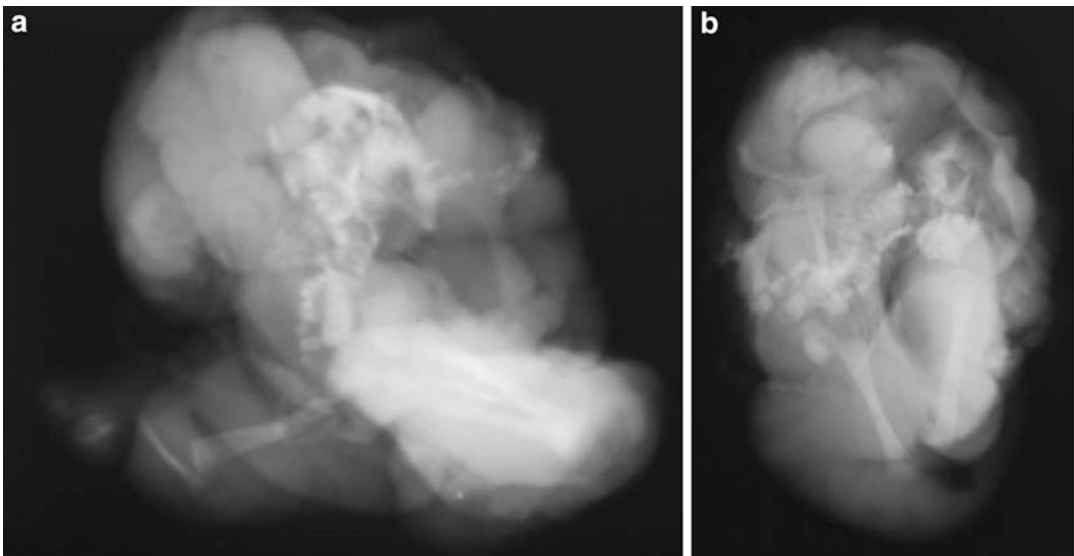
(a, b) Radiographs of the above acardiac fetus showing a missing head, cervical vertebrae and part of upper thoracic vertebrae, rudimental lower ribs, malformed
